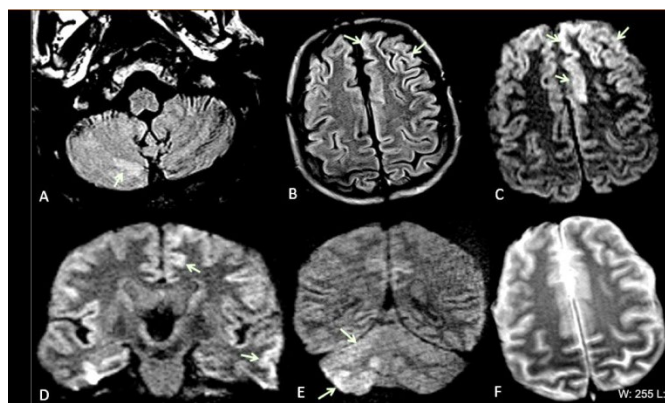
A 69 years-old-man presented with acute encephalopathy and seizures. (7) (A-B) Multifocal areas of FLAIR hyperintensity in the right cerebellum (arrows in A), left anterior cingulate cortex and superior frontal gyrus (arrows in B).
